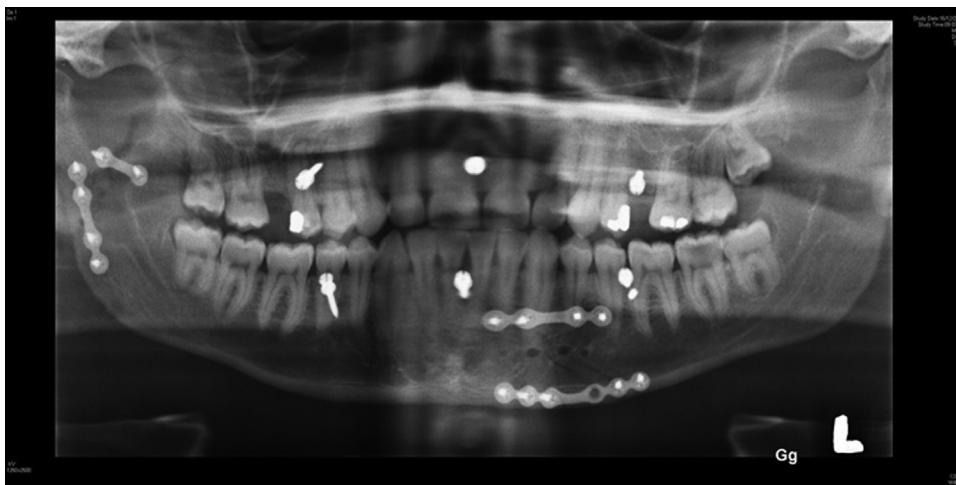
Panoramic radiograph shows separation of the main screw thread body from the head in between the LL6 and LL5.
